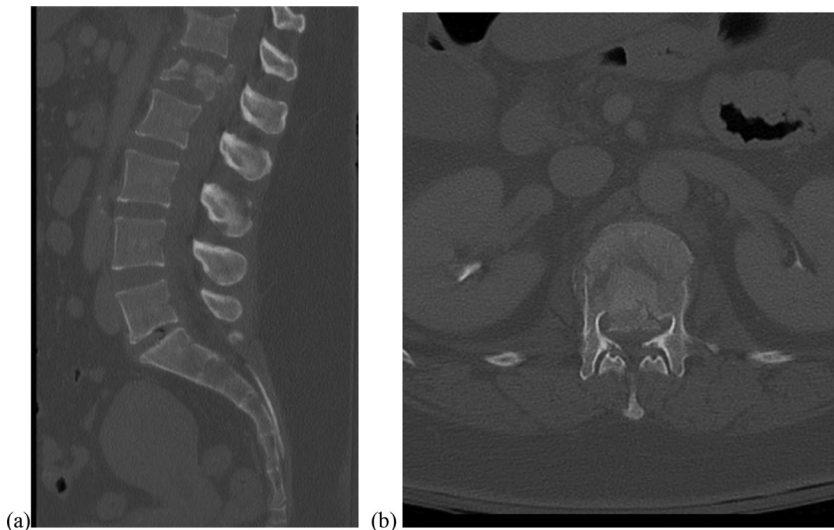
Representative mid-sagittal (a) and axial (b) CT cuts of L1 burst fracture with significant bony retropulsion.
